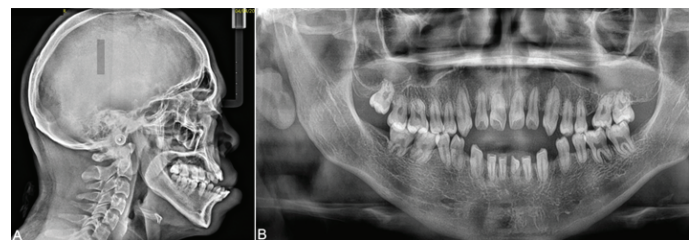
(A) lateral skull. (B). Panoramic radiograph
